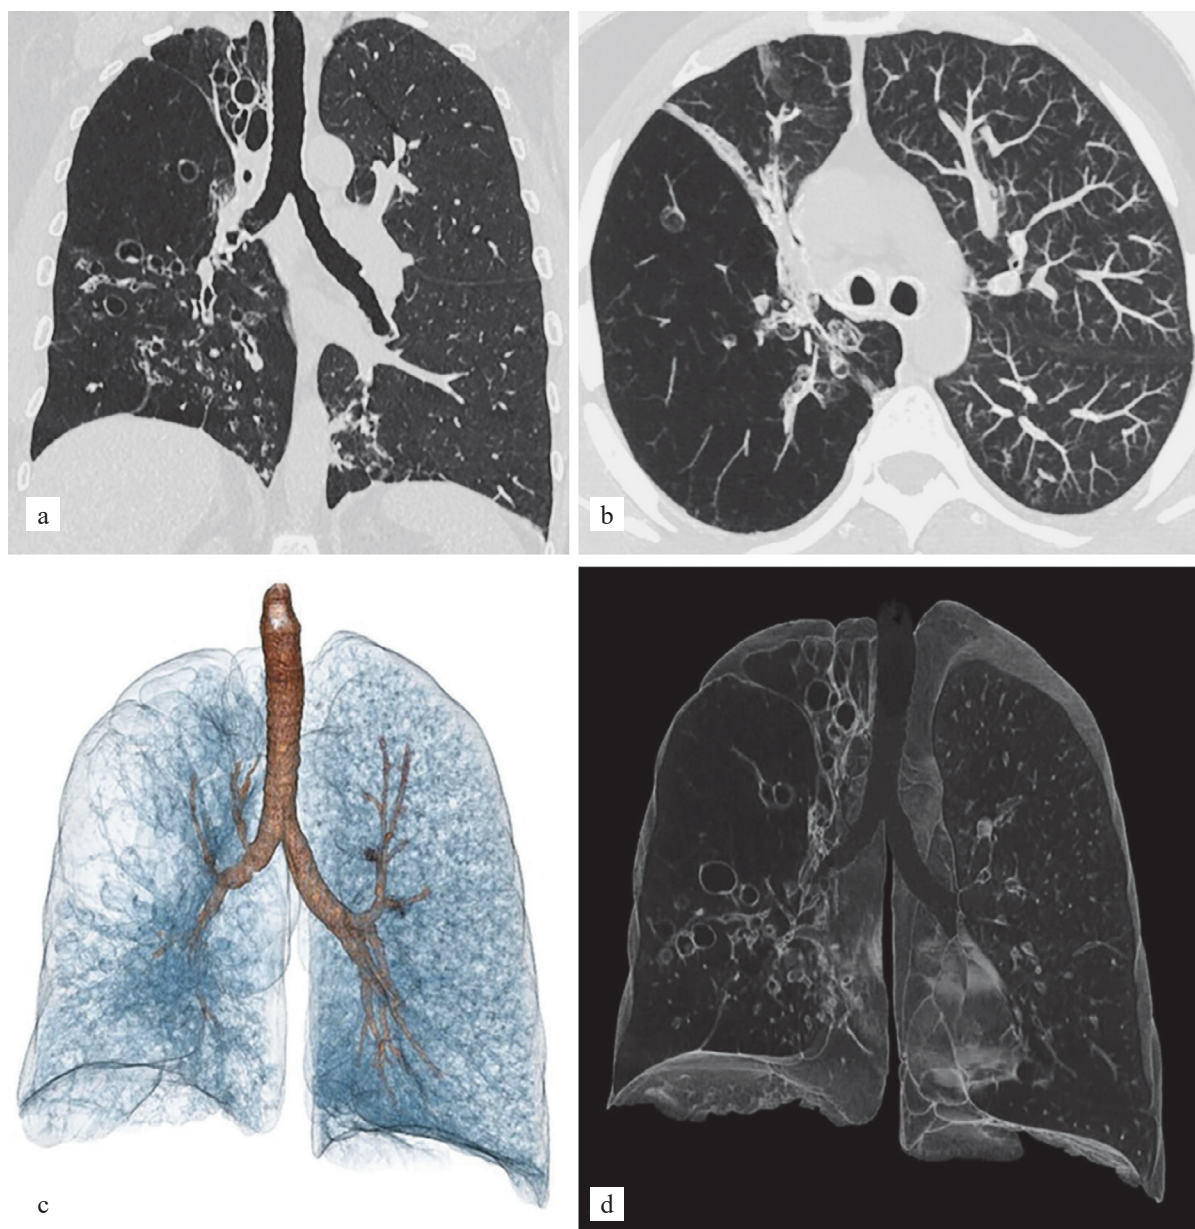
Computed tomography findings in an adult patient with Swyer–James–MacLeod syndrome: a, frontal projection; b, axial maximum-intensity projection; c, d, volume-rendered chest CT images show diffusely decreased attenuation of the right lung with signs of marked hypoperfusion and bronchiectasis, some with mucous plugging. There is volume reduction of the right lung, mainly in its upper lobe, with asymmetry of the pulmonary arteries, which are preserved in the left lung. (Source: L.P. Gomes de Farias et al. Swyer–James–MacLeod Syndrome: The Hyperlucent Lung. Radiology: Cardiothoracic Imaging)
